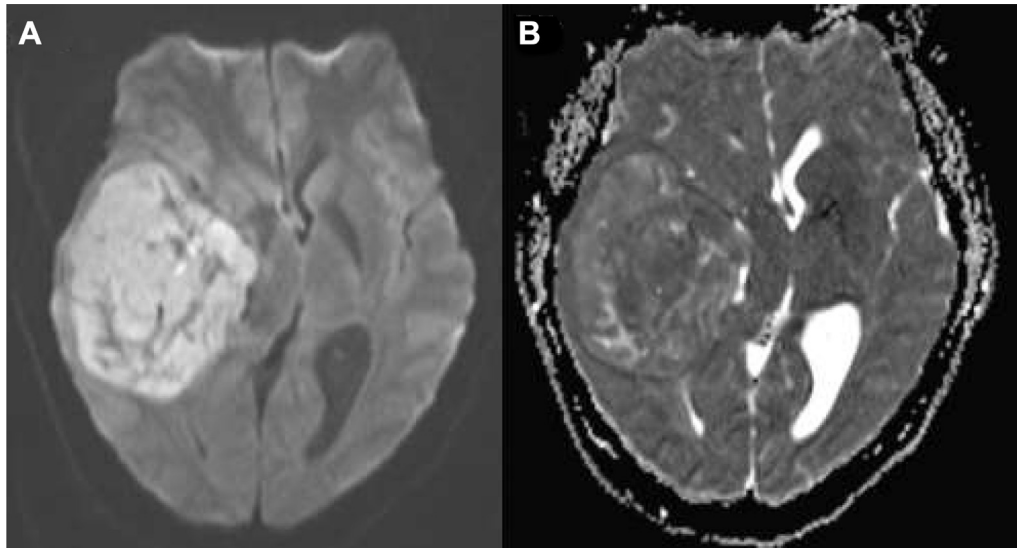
(A and B) show that the mass has most of its diffusion restricted on DWI, with a small area of unrestricted.
